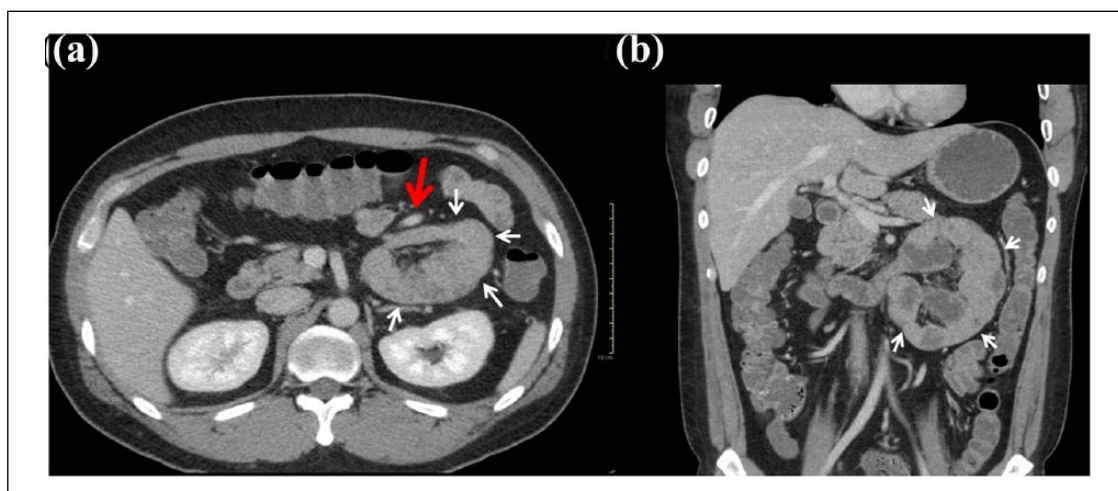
Contrast-enhanced computed tomography axial (a) and coronal (b) images show a nonobstructed left paraduodenal hernia as a cluster of small bowel loops in the left paraduodenal fossa (white arrows), which is bordered anteriorly by the inferior mesenteric vein (red arrow).
